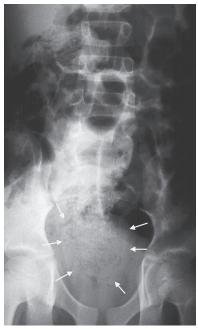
Abdominal x-ray. WA = large fecal mass in rectum
